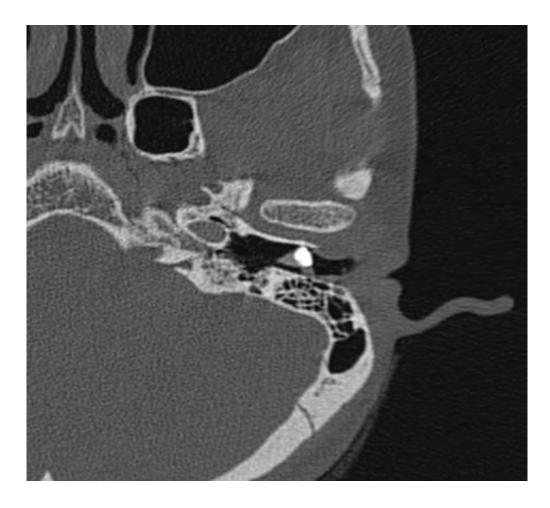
EAC Osteoma.HRCT axial image shows a pedunculated bone density lesion attached to the anterior wall of the left EAC through a stalk and almost obliterating the canal, suggestive of EAC Osteoma.
